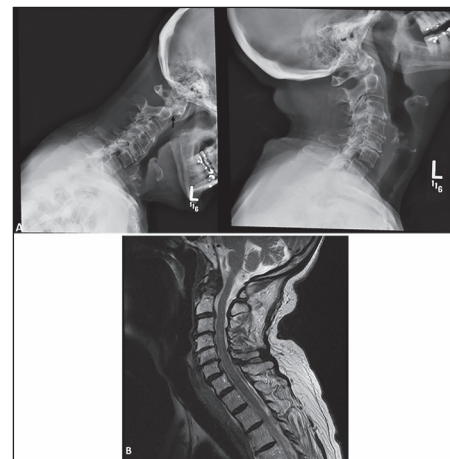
Two years post injury: (a) Flexion/extension X-ray demonstrating minimal movement of the fracture (arrow head). (b) Sagittal T2-weighted images demonstrating minimal reactive changes at the C1-2 complex
